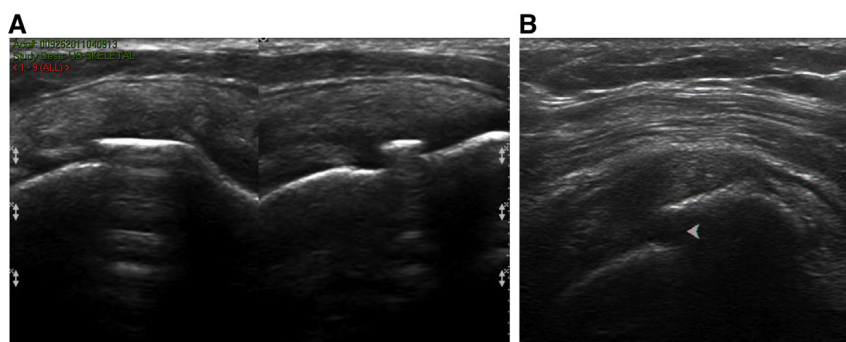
(A and B) Ultrasound images show signs of a greater tuberosity fracture (*arrowhead*).
